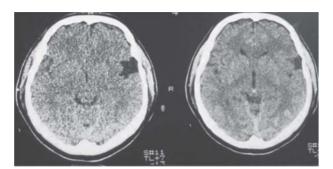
Brain CT scan one month after the head injury: Type 1 AC present on the right side of the MCF, no evidence of trauma or intracranial hemorrhage identified.
